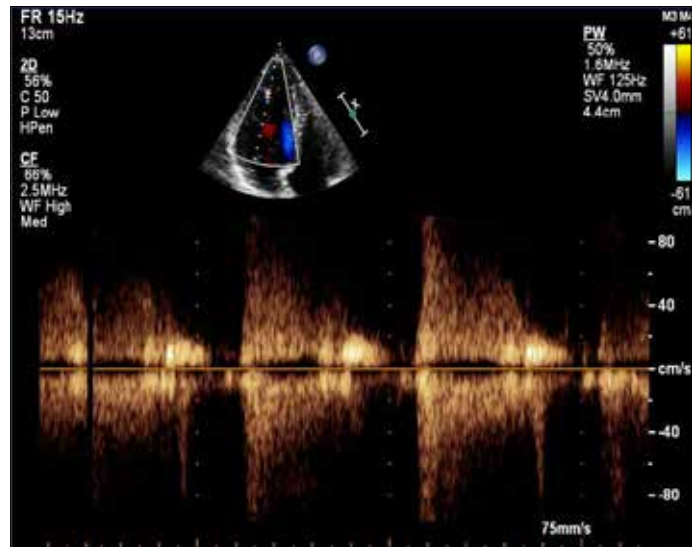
The pulse wave Doppler revealed particularly diastolic flow pattern
